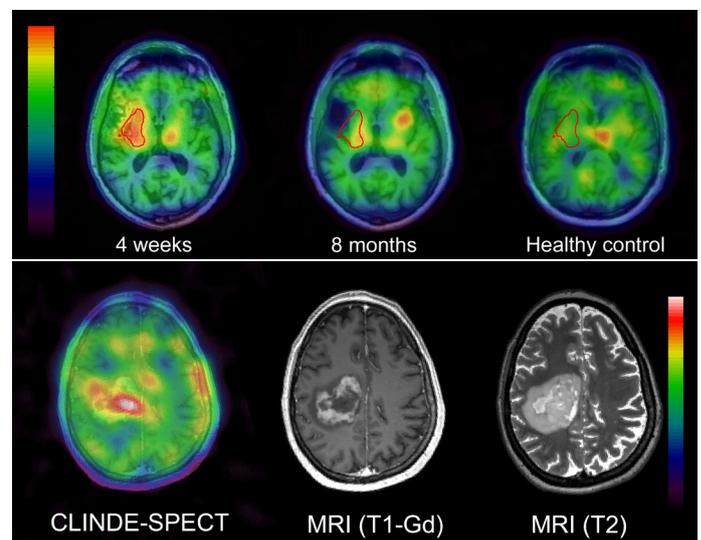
(Upper panel) [ $^{123}\text{I}$ ]CLINDE SPECT images showing the spatial and temporal development of inflammatory responses (i.e. TSPO expression) in an MCA stroke patient 4 weeks (left) and 8 months (middle) after a stroke. Clearly, 8 months after the stroke TSPO expression in the region adjacent to the infarct (red circle) was reduced to near normal level as compared to (right) an age, gender and TSPO-genotype matched healthy volunteer. (Lower panel) [ $^{123}\text{I}$ ]CLINDE SPECT and two MRI scans from a 31 year old female patient with multiple sclerosis. Clearly, an increased binding of [ $^{123}\text{I}$ ]CLINDE to TSPO is seen in the severe plaque that is present. Courtesy of Ling Feng and Per Jensen.
